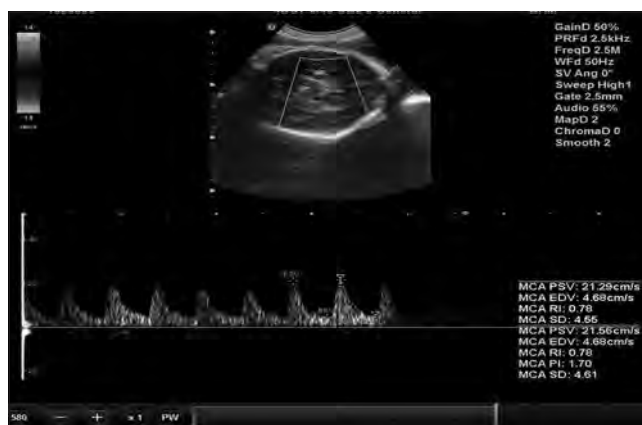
Doppler ultrasound of the middle cerebral artery of the first donor twin showing normal Doppler indices
